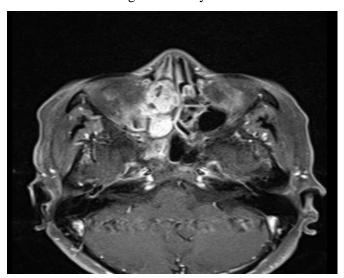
MRI Contrast T1 weighted image shows homogenously enhancing soft tissue lesion in right nasal cavity and ethmoid sinus.
